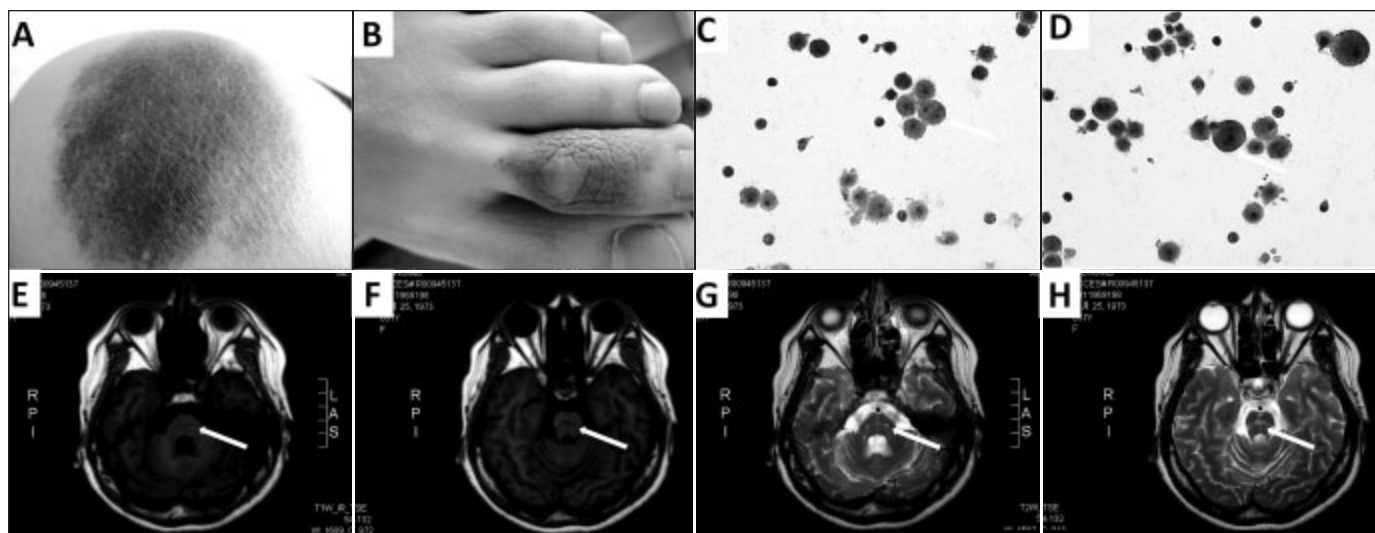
Clinical manifestations and imaging findings. Melanocytic skin lesions on one shoulder (A) and foot (B). Malignant melanoma cells were found in cerebrospinal fluid (C and D, white arrows). T1WI shows hyperintense lesions in the central section of the pons (E and F). T2WI displayed a typical “hot cross bun” sign and atrophy in the pons (G and H). Three brain MRI examinations were undertaken approximately six months apart did not show any evolution of the above-mentioned lesions.
